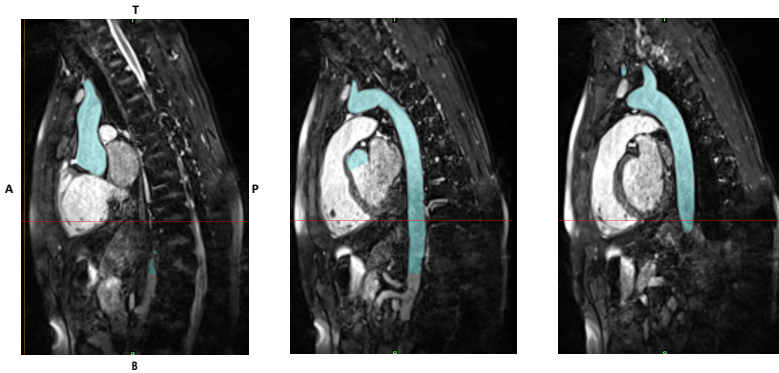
MRI images of a 39 years old male volunteer, applied to extract the geometry of the aortic arch (indicated in blue).
